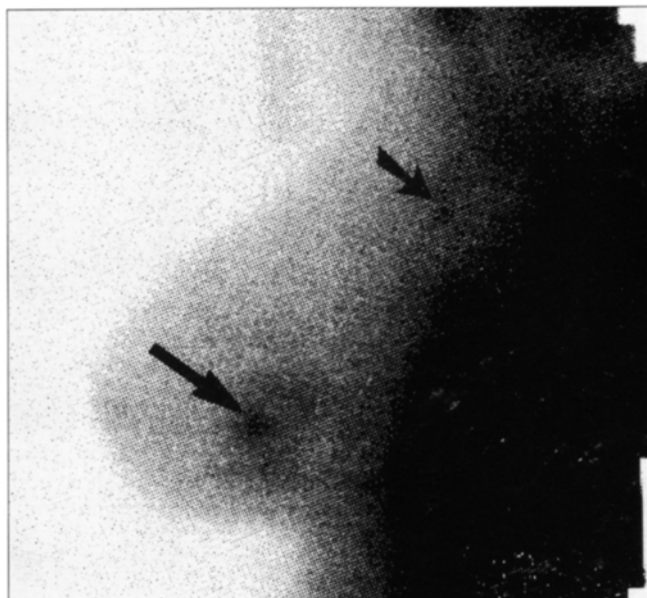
Prone scintigraphy demonstrates a breast cancer in a 49-year old female with a palpable mass in the left breast. Intense sestamibi uptake (long arrow) occurred in the mass. Surgical biopsy confirmed intraductal breast cancer. Axillary nodal activity (short arrow) resulted from breast cancer metastases.
